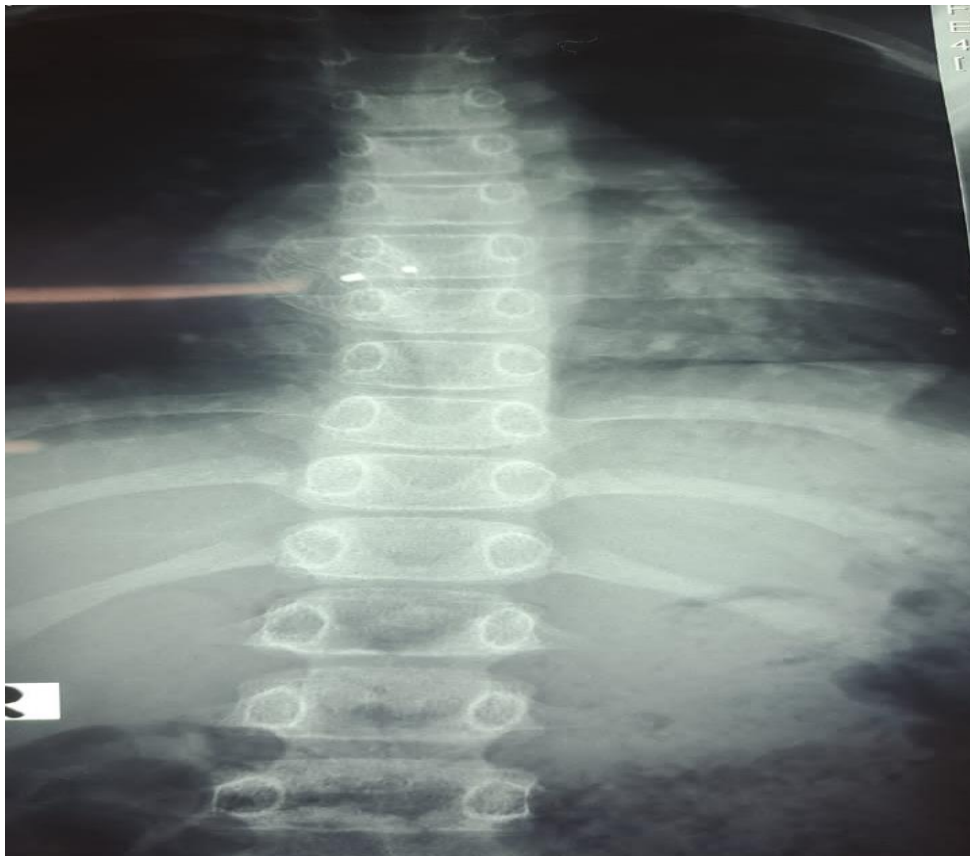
X-ray spine showing Butterfly vertebra
